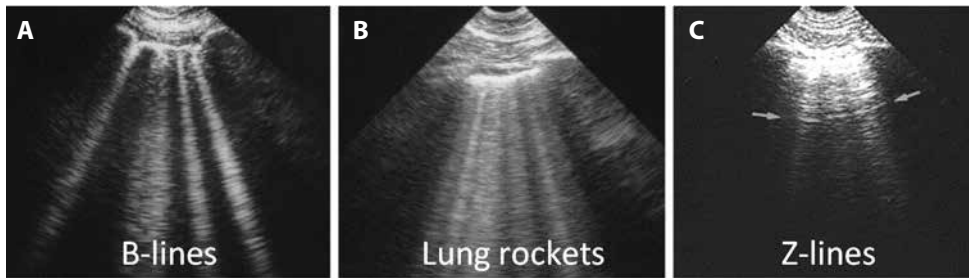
Interstitial syndrome: lung-rockets; A — presence of four or five B-lines, called lung rockets (here septal rockets correlating with thickened subpleural interlobular septa), suggestive for lung oedema; B — presence of twice as many B-lines, called ground-glass rockets. Suggestive for severe pulmonary oedema (with ground glass areas on CT); C — Z-lines for comparison. These 'parasites' are ill-defined, short, and do not erase A-lines (arrows). Adapted from 'Lung ultrasound in the critically ill' [11]
